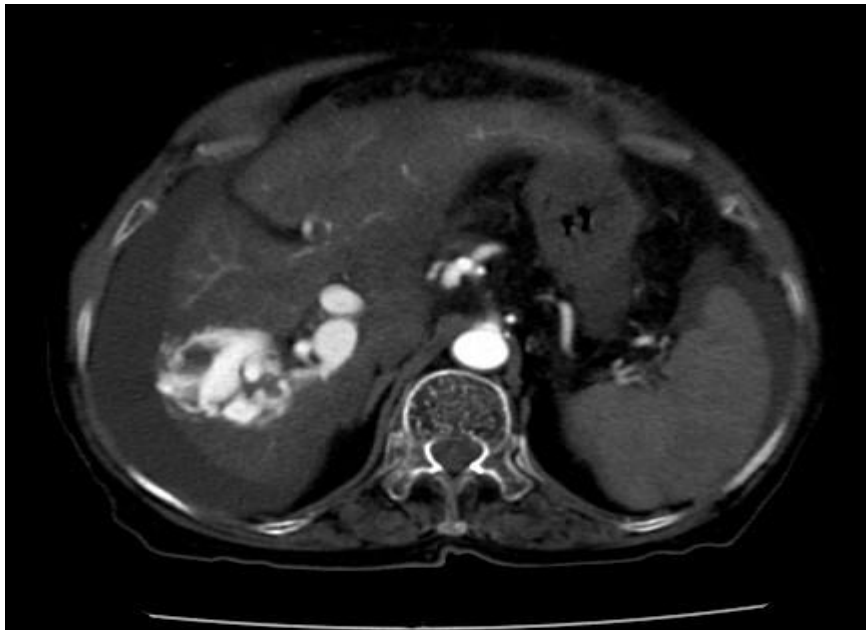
CT Scan in arterial phase
